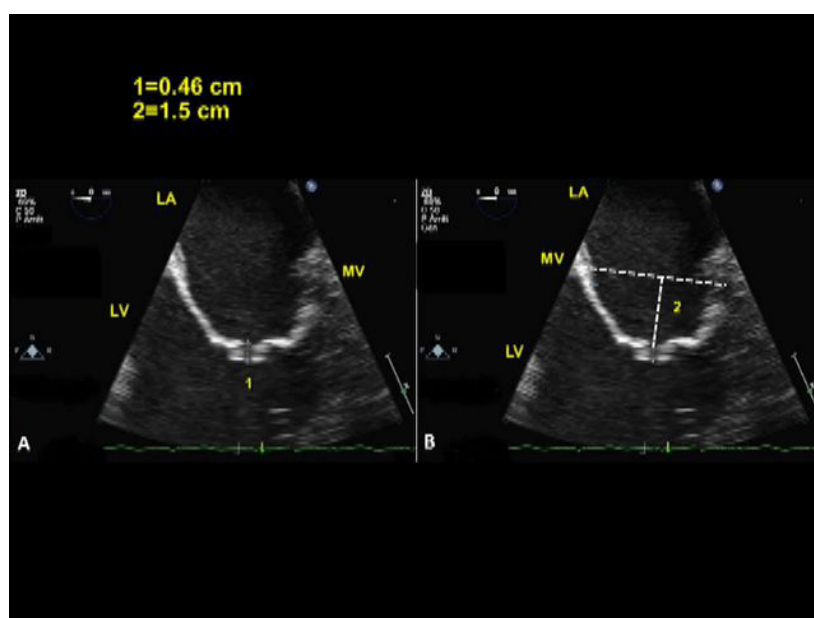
Two-dimensional transesophageal echocardiography demonstrates systolic non-coaptation gap (1) of the MV which is displaced into the LV. #2 represents the perpendicular distance of the MV coaptation point from the MV annulus. LV: left ventricle; LA: left atrium; MV: mitral valve. Copyright with Aiman Smer
